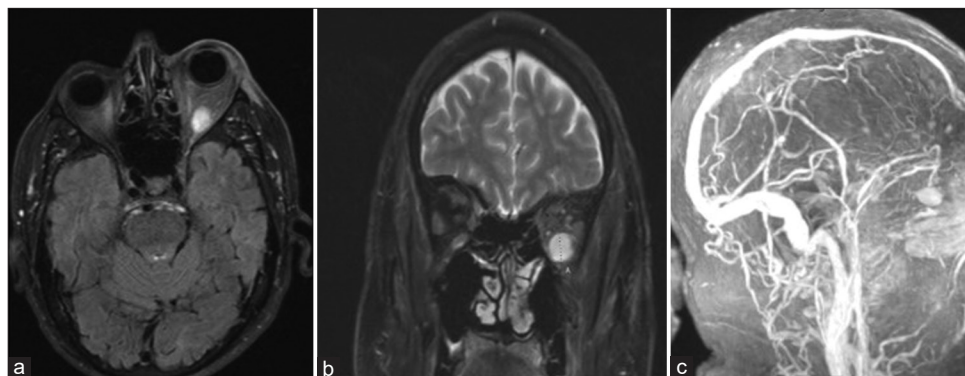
Magnetic resonance imaging angiogram axial (a), coronal (b), sagittal, and (c) showing hyperdense left inferior intraconal hyperdense well-circumscribed mass in the left orbit.
